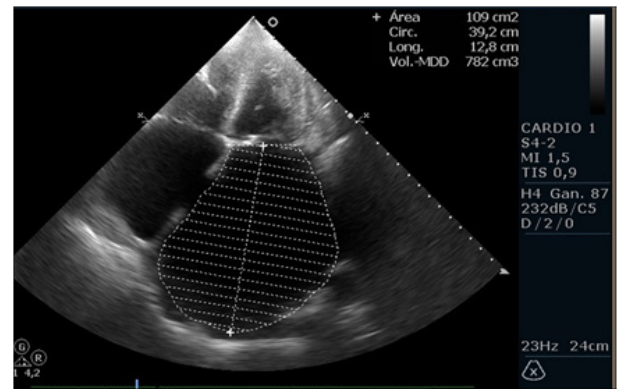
Apical echocardiographic view of four cameras with left atrial area measurement widely increased (109 cm²) and inferosuperior distance of 12.8 cm
